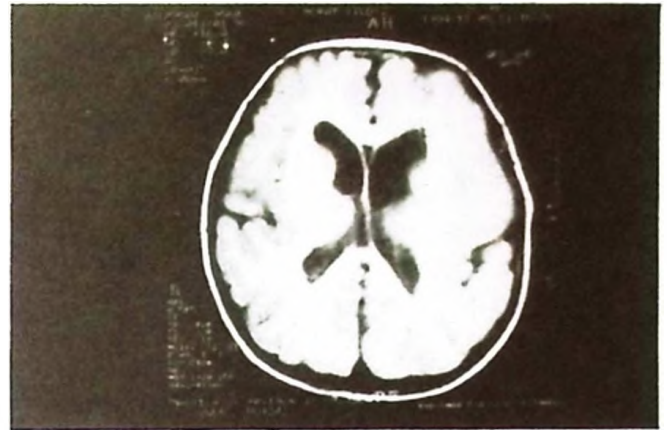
Cranial MRI of Case 5 (grade 3 lissencephaly, axial view).
